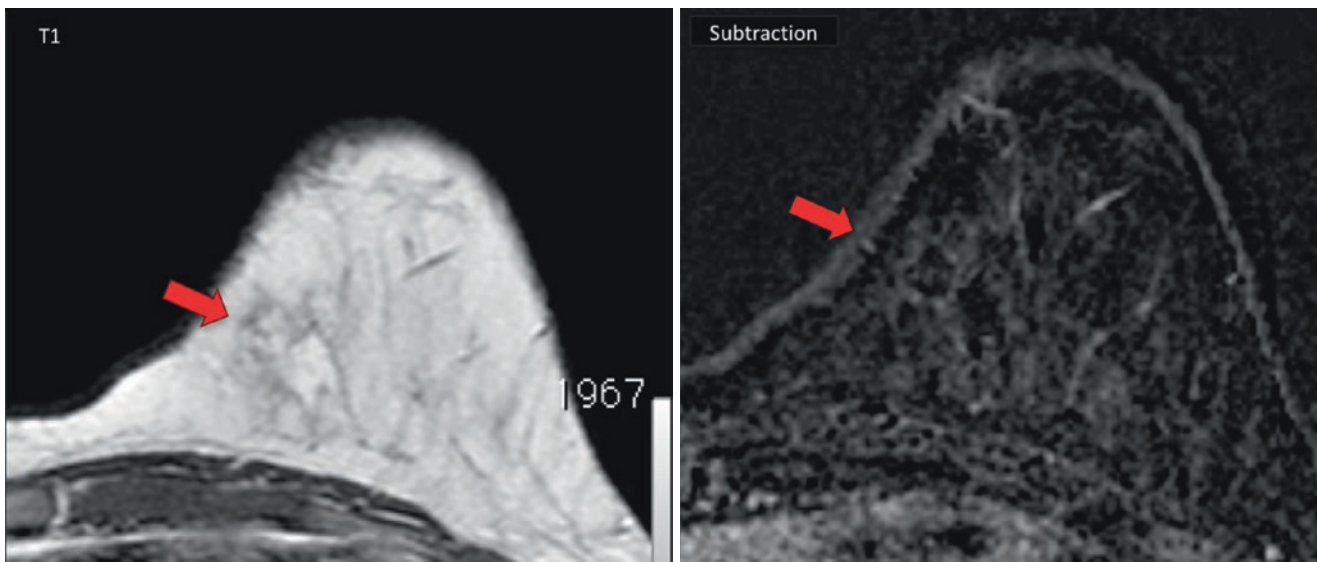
Patient with a personal history of lipofilling for aesthetic reasons. After some time, she presented with a palpable lump at that location. However, conventional imaging tests (mammography and ultrasound) were completely normal. For that reason, an MRI was performed. Only a slight fat trabeculation in that area was seen, without
